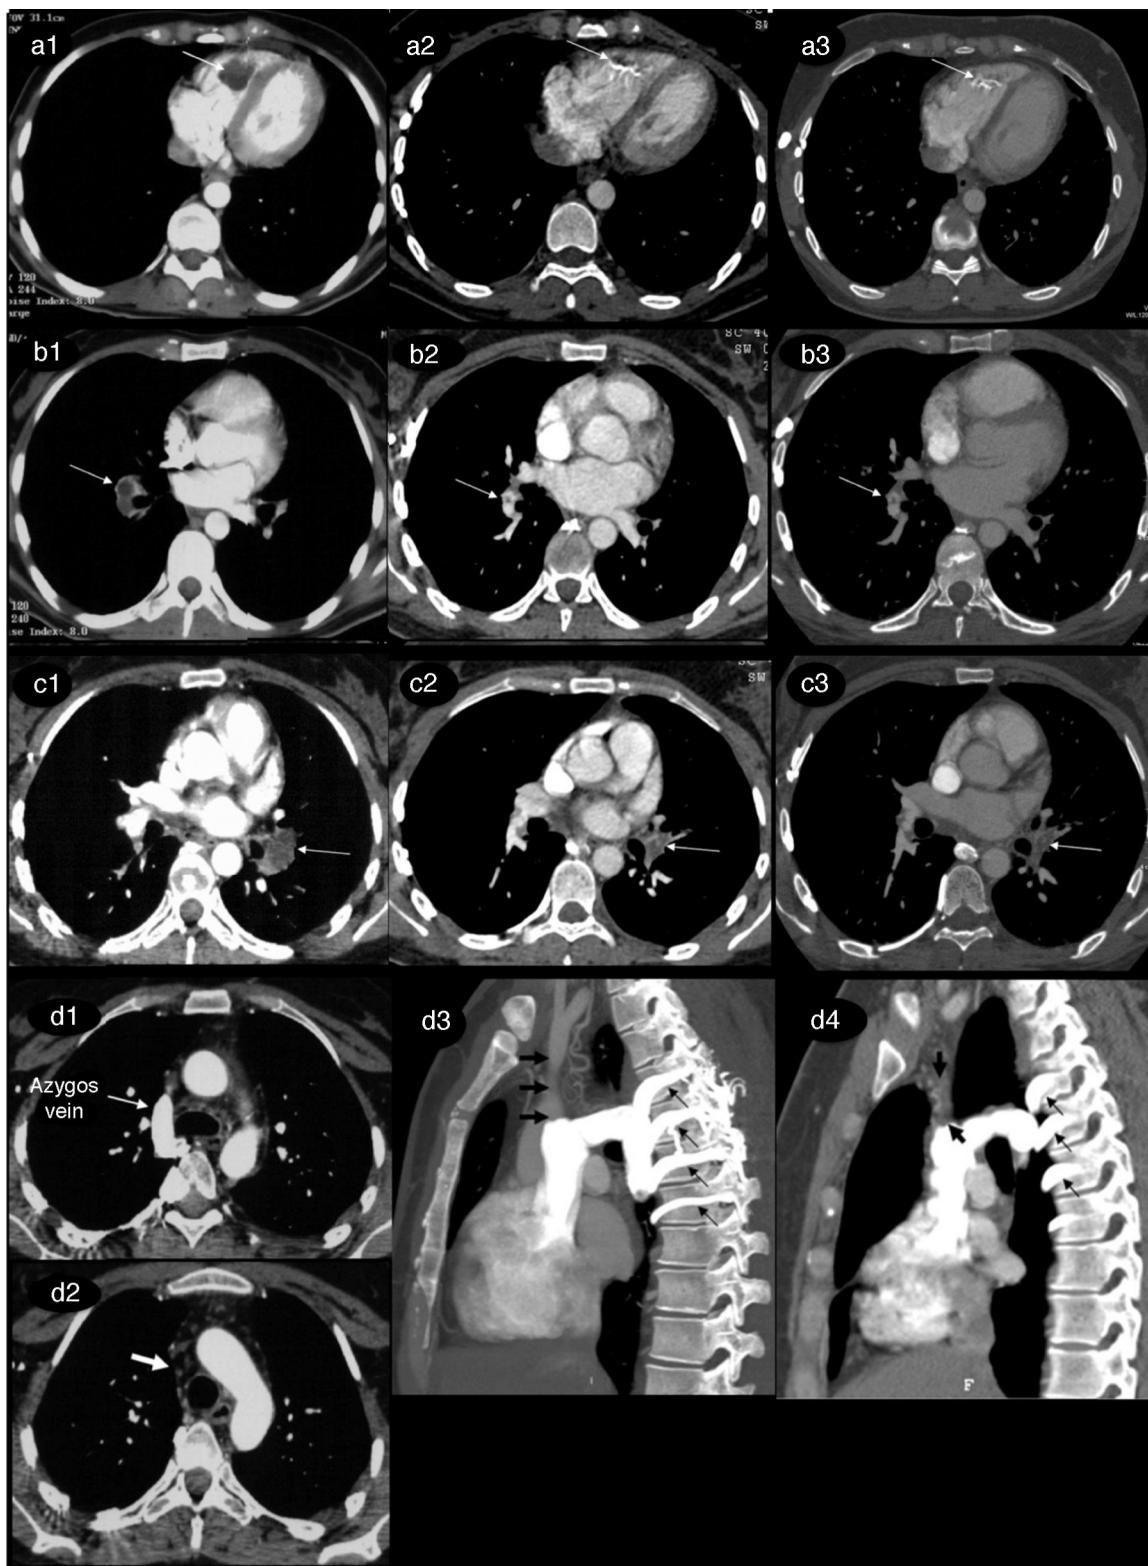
Five-year computed tomography angiography (CTA) follow-up of thrombi in the intracardiac region, the superior vena cava, and both pulmonary arteries.
